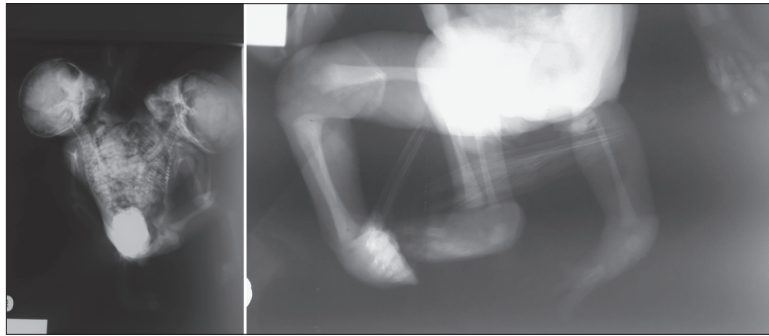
Postmortem X-ray shows two separate spines and visible third limb with one bone
